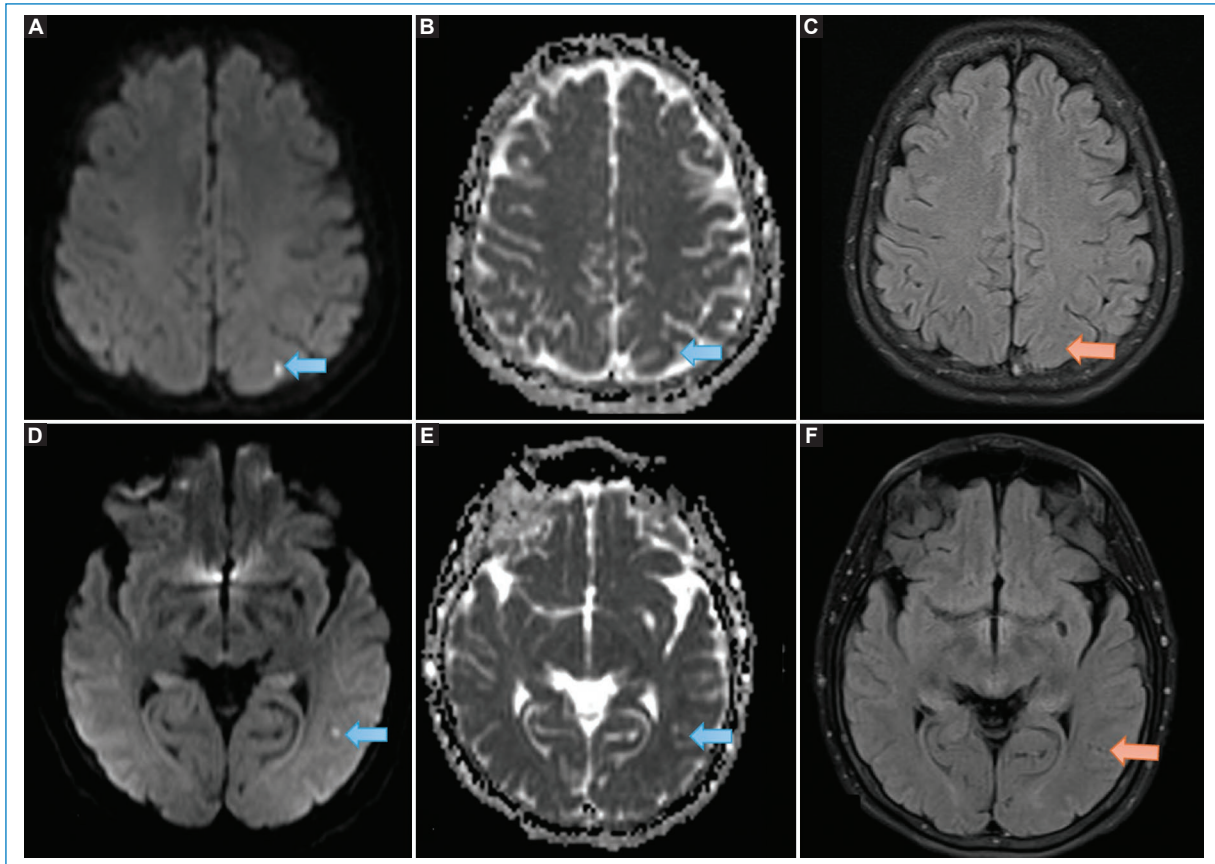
Lesions in the left parietal and occipital regions, presenting restriction on DWI diffusion sequences and ADC mapping (A, B, D, and E), without representation on FLAIR sequences (C and F), consistent with an acute ischemic event (orange arrows).
